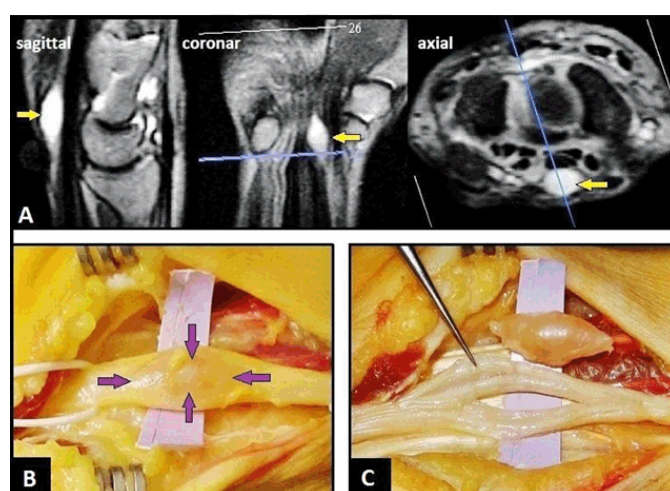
(A) Preoperative magnetic resonance imaging scan demonstrating hyperintense signal of the oval and strictly demarcated tumor within the median nerve, (B) Intraoperative clinical photograph showing the intraneural encapsulated Schwannoma before excision (arrows), (C) Intraoperative clinical photograph showing the complete excised Schwannoma without fascicle lesions after that.
